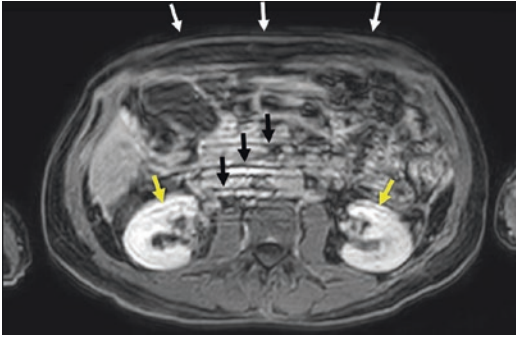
A 62-year-old woman with clinically suspected cirrhosis: axial T1-weighted gradient echo Dixon-based fluid image of the abdomen. Despite using breath-holds, ghost artifacts (black arrows) are evident along the anteroposterior phase-encoding direction that overlay the kidneys (yellow arrows), and are caused by motion of the anterior wall (white arrows)
